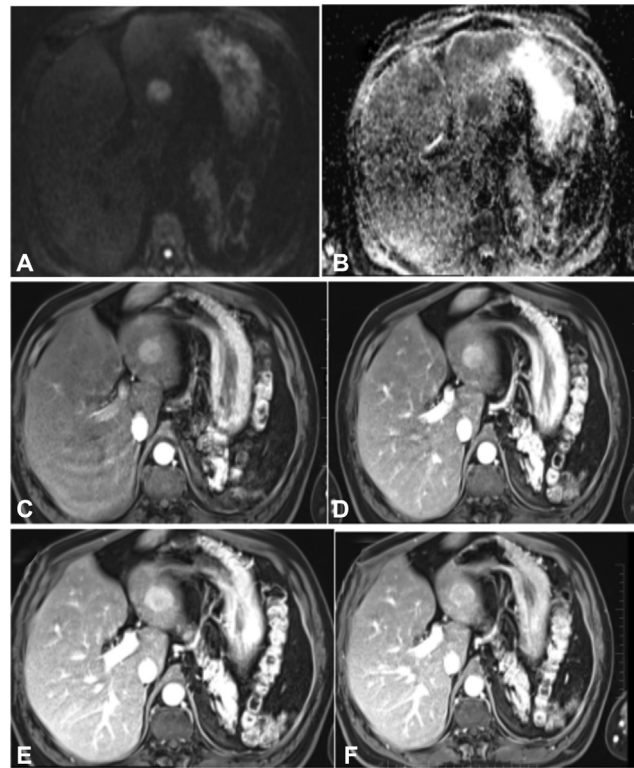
(A and B) Lesion appear hyperintense in DWI with signal drop in ADC, showing diffusion restriction. (C and D) Early and late arterial phase enhancing lesion in left lobe of the liver. (E and F) Heterogeneous enhancement of the lesion in the portal phase and mild washout in 10-minute delayed phase images.
